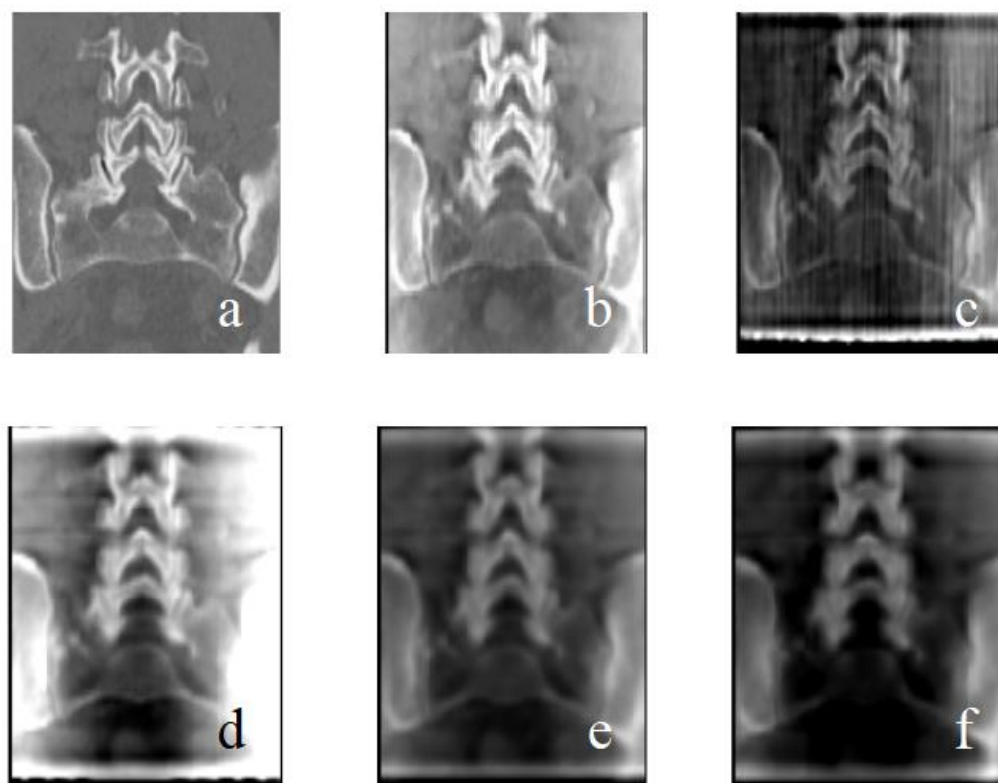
Example of coronal view for different methods. (a) planning CT, (b) FDK, (c) SART, (d) OS-SART, (e) ADMM-TV, (f) ADMM-W.
